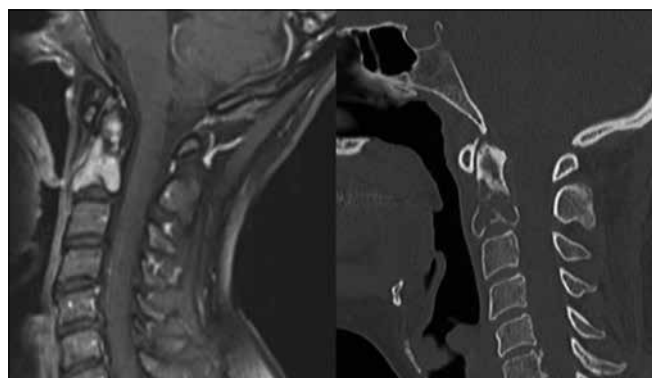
A 44-year-old female with a previous history of breast cancer presenting with new-onset of neck pain associated with head rotation and extreme flexion. Magnetic resonance imaging (left) demonstrates the involvement of tumor within the C2 vertebra and odontoid process with significant bony loss and unicortical defect on computed tomography imaging (right)
